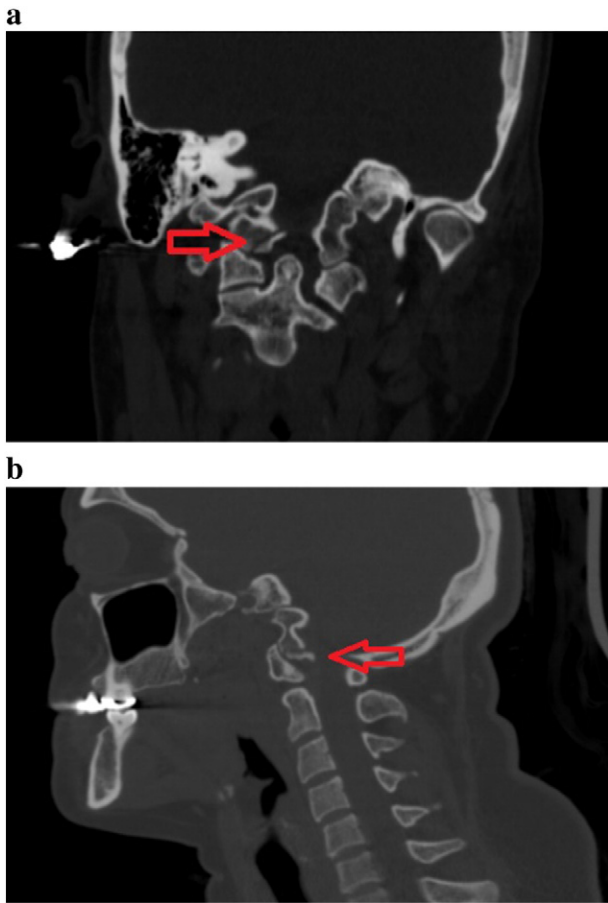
a. The arrow shows the fracture of the occipital condyle on coronal plain cervical CT of the patient. b. The arrow shows the fracture of the occipital condyle on sagittal plain cervical CT.
